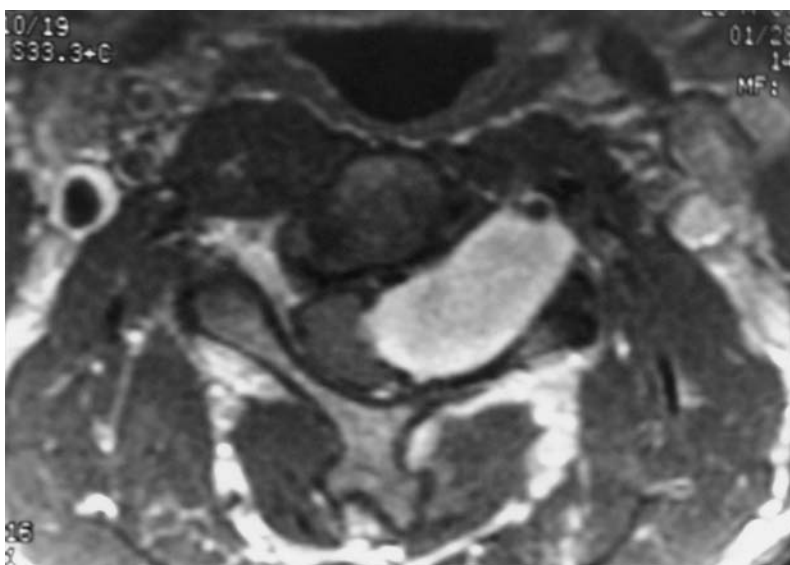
Axial T1-weighted MRI after contrast administration shows a dumbbell-shaped cervical spinal schwannoma.
